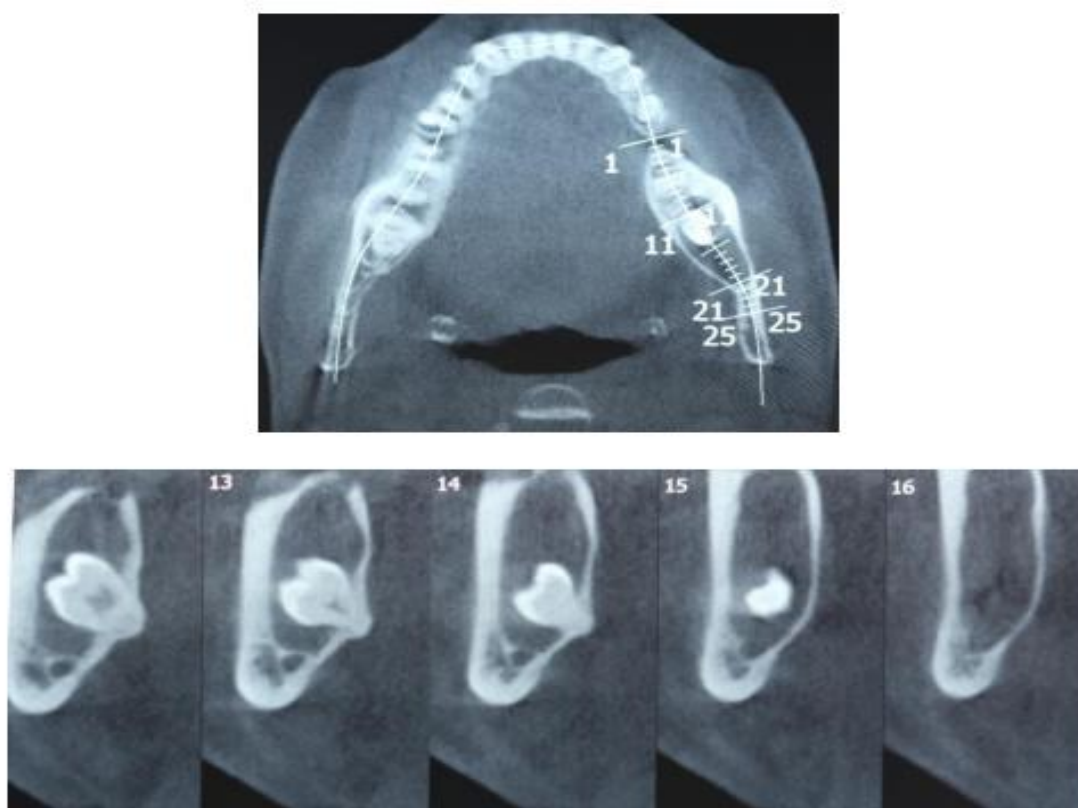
CBCT scan images of a deeply impacted third mandibular molar with dentigerous cyst
